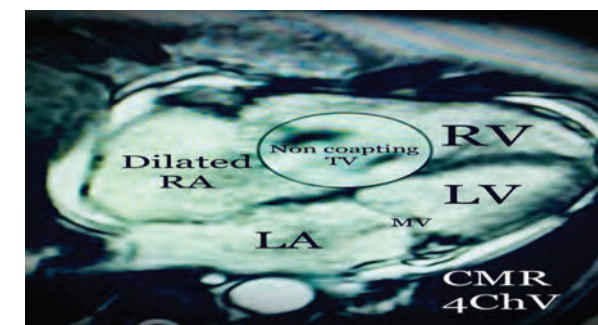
Cardiac MRI (CMR) showing Tricuspid valve (TV) was not coapting normally.
